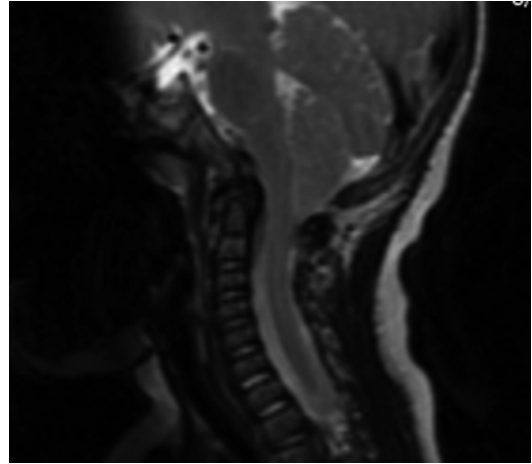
A 4-month-old boy presented with torticollis but without tightness of the sternocleidomastoid muscle and having full cervical spine motion. The MRI scan demonstrates an Arnold-Chiari malformation with the cerebellar tonsils protruding into the foramen magnum and ending at the level of the C2 spondylodysplasia
